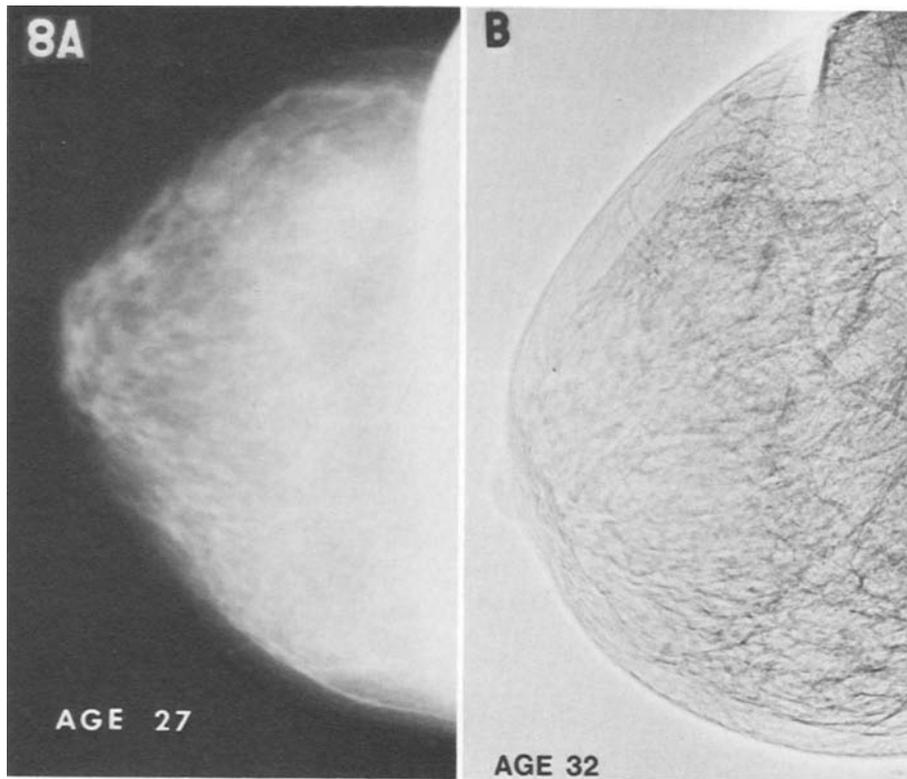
Radiographs taken 5 years apart. Although the patient was only 27 at the time of the initial examination, the P2 pattern persists. The later study reveals only some diminution in the overlying dysplasia. One would not expect to see a significant change in the appearance of the breasts for the rest of the patient's life.
